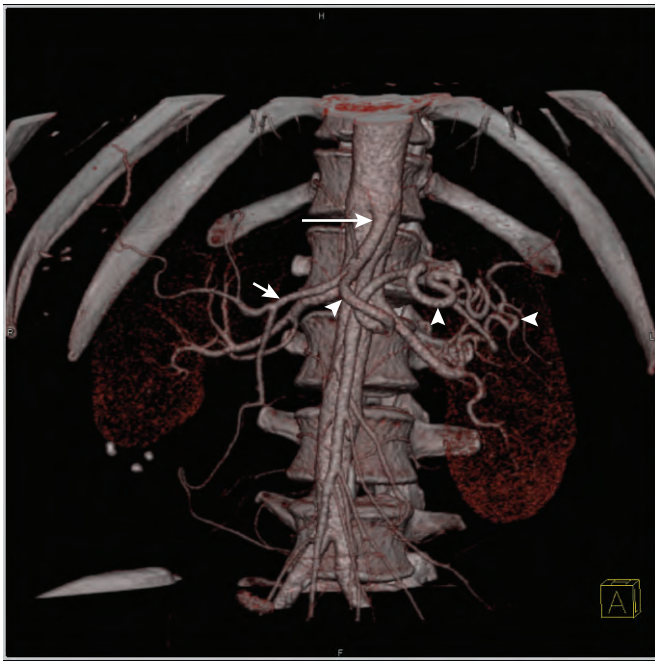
Thirty-year-old woman being evaluated for renal organ donation by three-dimensional, volume-rendered, anteroposterior projection, multidetector row computed tomography of the splenic artery (arrowheads), celiac axis (long arrow), and hepatic artery (short arrow).
